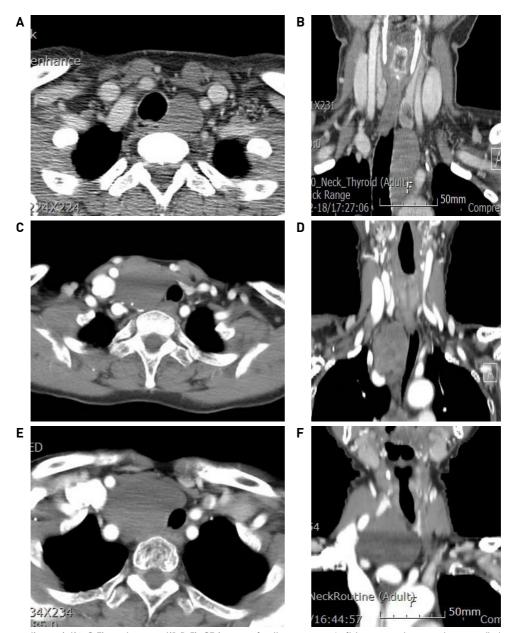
Preoperative axial(A,C,E) and coronal(B,D,F) CT images for three cases. Left lower neck mass shows well defined cystic mass on lower portion of the left thyroid gland. It compresses the trachea mildly to the right side and involves upper mediastinum(A,B), Right cystic mass compresses the trachea severely to the left side and involves upper mediastinum(C,D), and more huge and more severely compresses the trachea severely to the left side and involves upper mediastinum(E,F). No enhancement of the mass suggests that the lesion is cystic. CT; computerized tomogram
